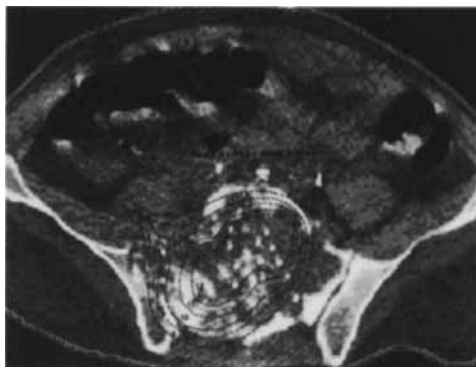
Computed tomography of the lumbosacral area. Large tumor mass involving the vertebral bodies of L4, L5, and S1 on the right side as well as involvement of the right sacro-iliac joint and extension across midline to the left.
